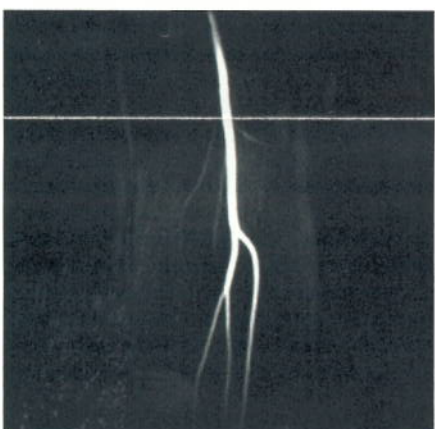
2D PCA of popliteal trifurcation, V_{OPT} 45 cm/s, sequence used was fl2d_pc_45_45_45_9fb108.wkc, TR 81 ms, TE 9 ms, Flip 11 deg, FOV 275 mm, 6/8 RecFOV, no swap, matrix 144x256, slice thickness 70 mm, 2 acquisitions, coronal, cardiac triggered with 100 ms trigger delay and 5 phases, scan time 4+ min, MAGNETOM Vision, CP Extremity coil. The best three acquired cine images were combined (averaged) and filtered (F:7) for optimal presentation, but no MIP was involved. (Courtesy of N.E. Indiana MRI)
